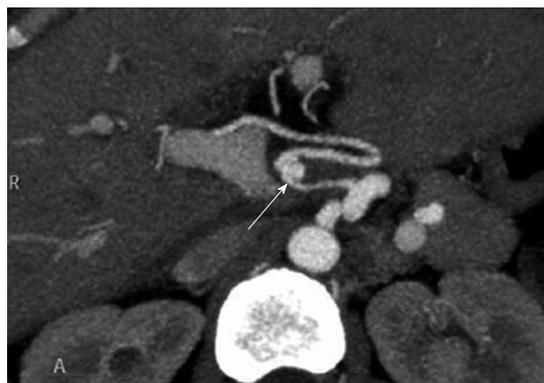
Contrast-enhanced-multidetector-row computed tomography-scan showing a hepatic artery pseudoaneurysm following orthotopic liver transplantation. Pseudoaneurysm (arrow).
